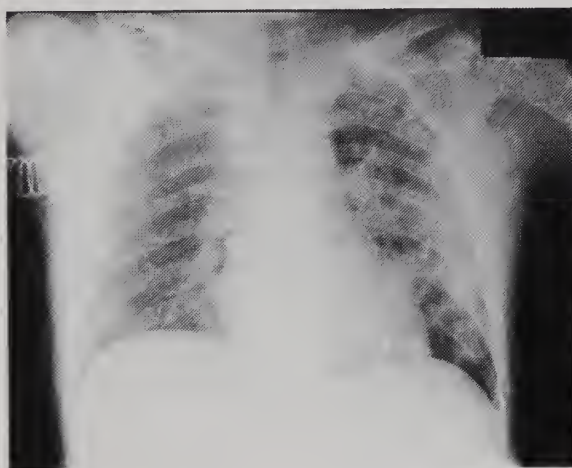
Chest roentgenogram 1 hour after aspiration of barnyard manure.
